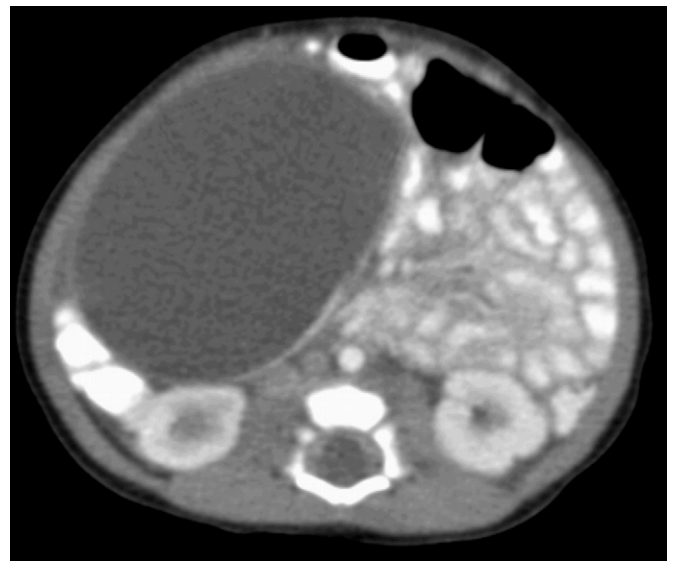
Computed tomography scan demonstrates a large cystic mass in the region of the head of the pancreas that turned out to be a duodenal duplication. (Courtesy Dr. Aimen Shaaban.)
